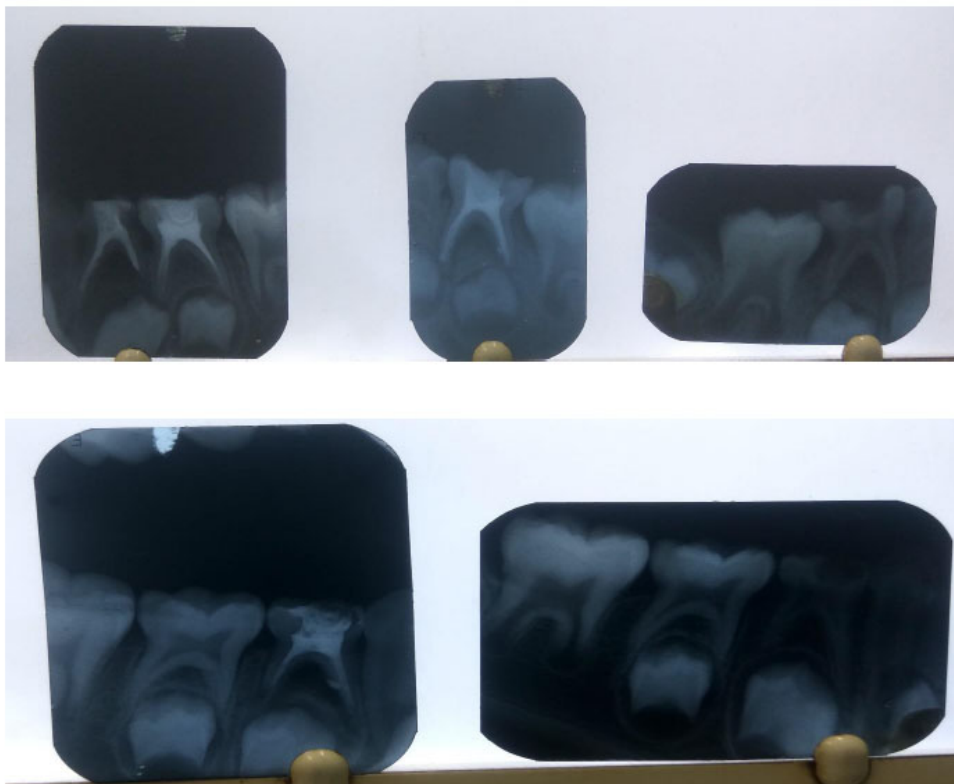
Intraoral periapical radiographic images of mandibular molars: an overview.
